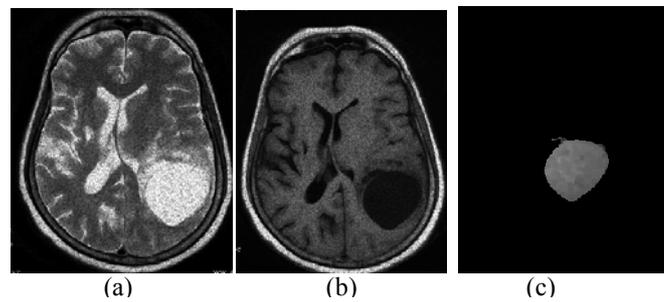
shows the example for checking performance of AGASA on speckle noise added images of 20dB SNR. (a) T2- weighted (b) T1- FLAIR (c) segmented tumor
